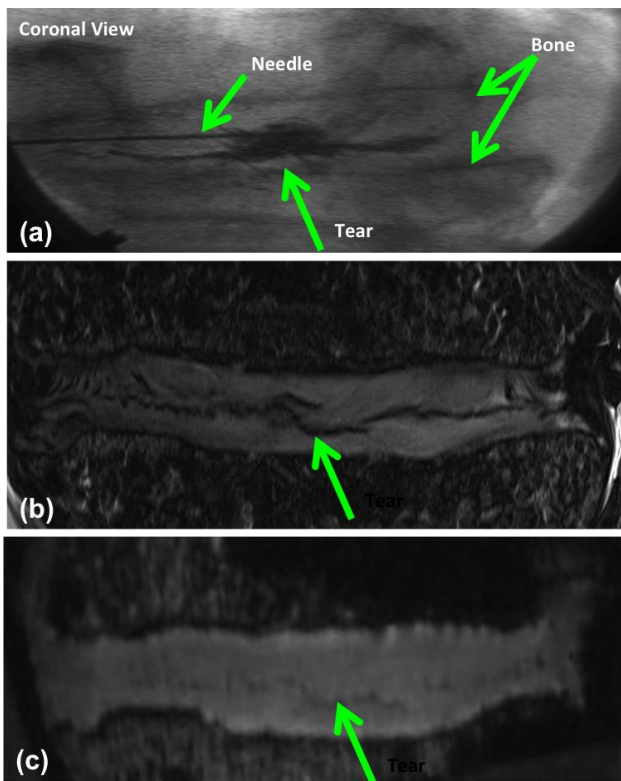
Three matched images of a radial tear with different imaging: (a) fluoroscopic coronal view with radiographic dye, (b) T2 weighted TSE, and (c) T1 weighted FLASH
